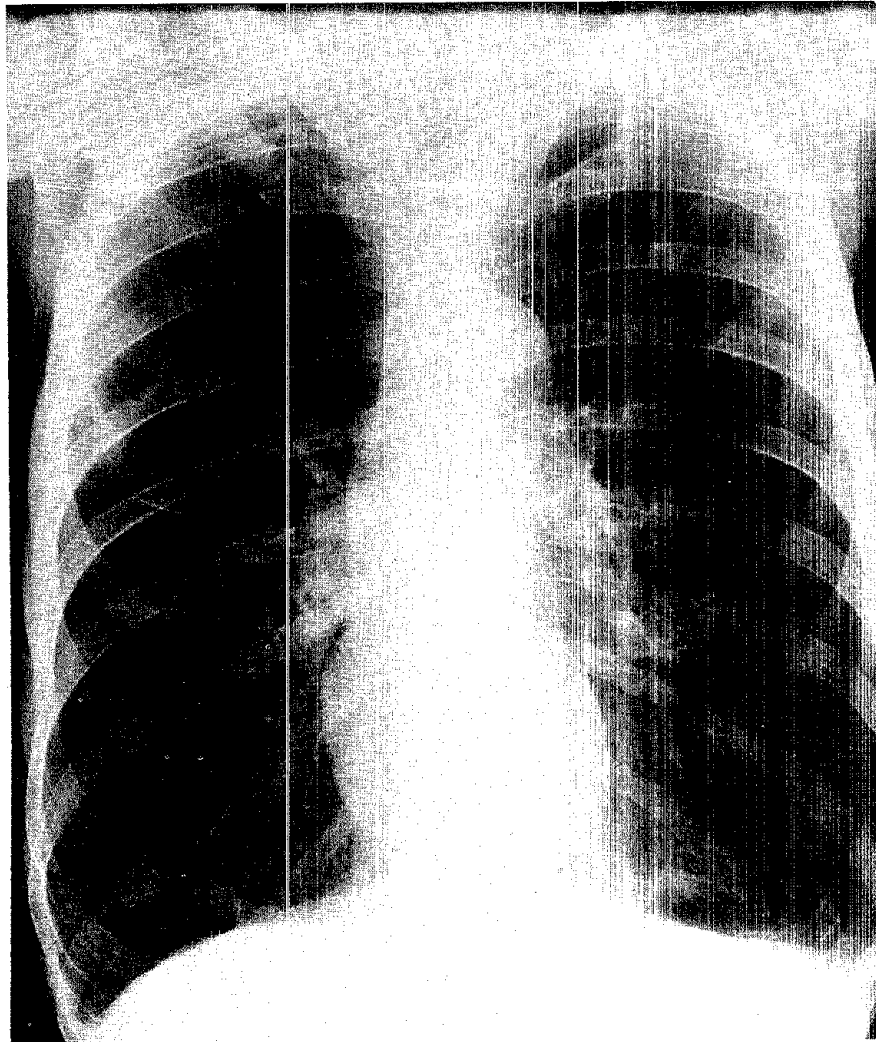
Incorrect position, posteroanterior chest radiograph, with the scapula overlying the lung field.
